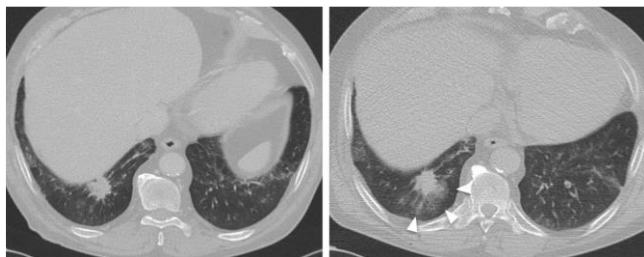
CT-guided chest biopsy of a pulmonary nodule. (a) Axial CT image before the procedure showing a pulmonary nodule in the right lower lobe. (b) Postprocedural axial CT image demonstrates perilesional haemorrhage as ground-glass opacity around the nodule (arrows)
